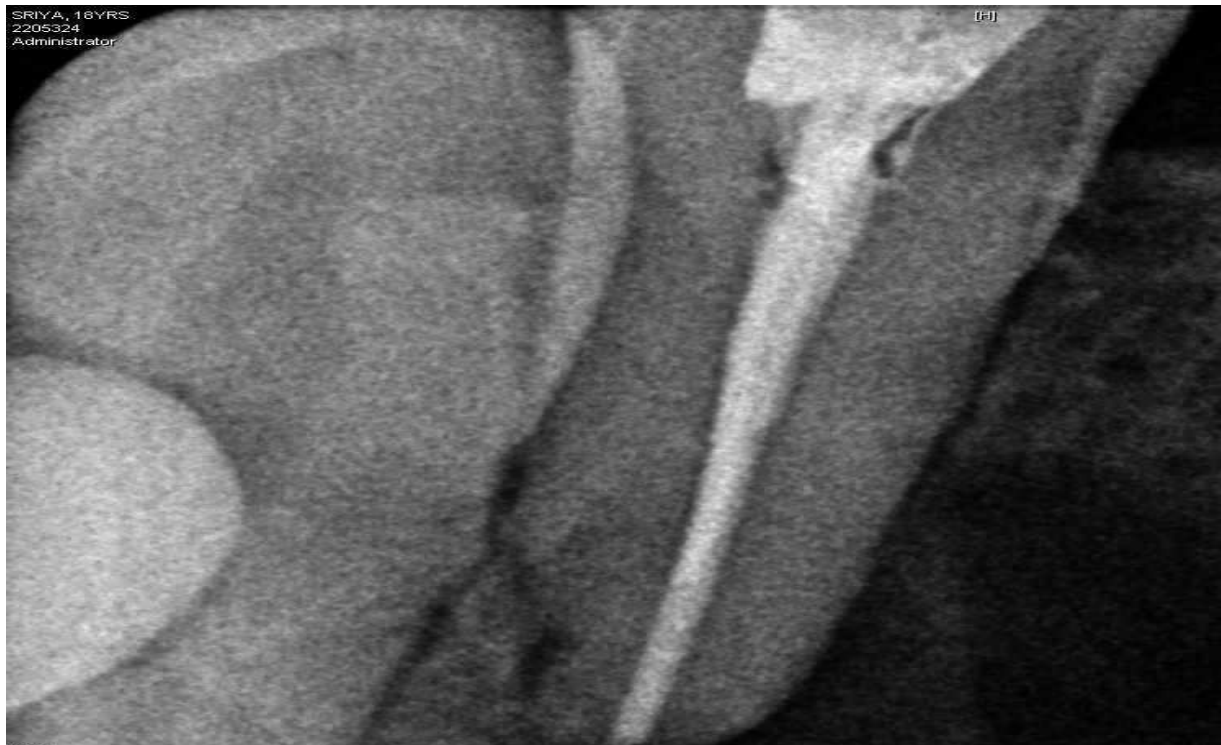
Pre operative radiograph after root canal treatment
